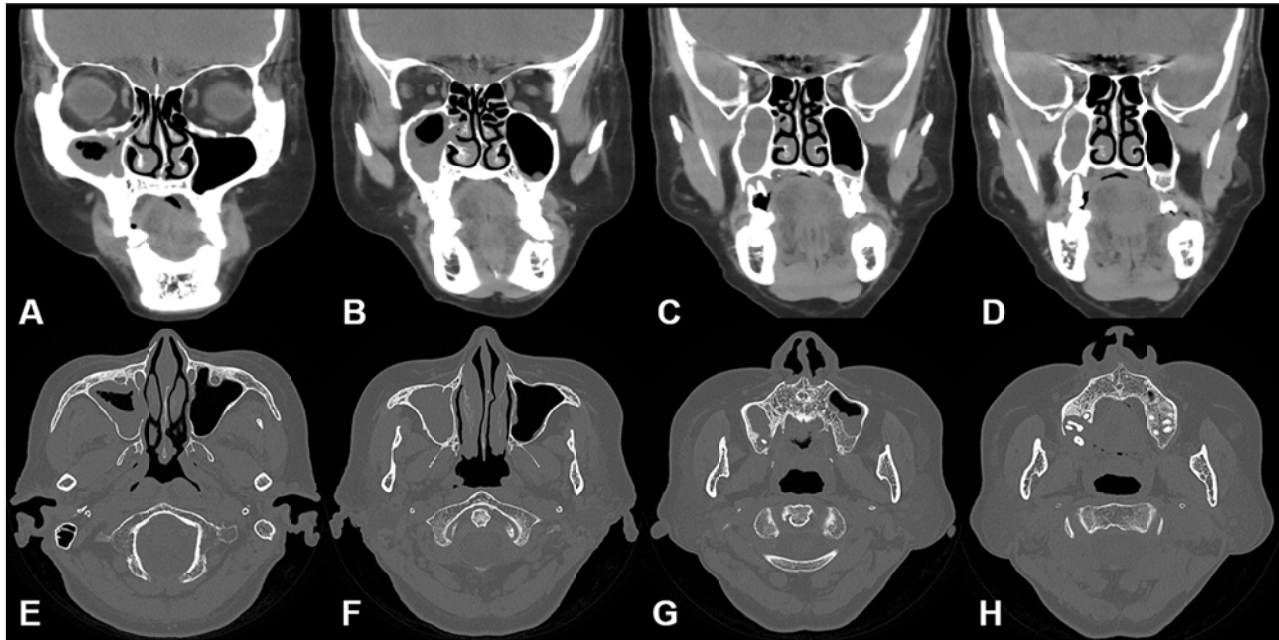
Preoperative facial CT views: Coronal view (A~D), Axial view (E~H).
